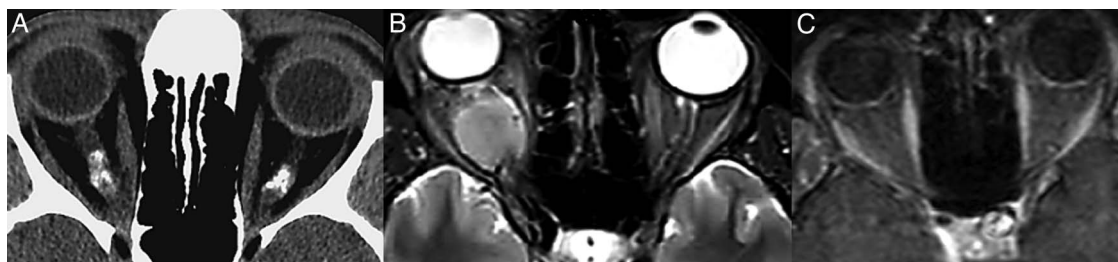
(A) CT of the orbits (axial view) revealing calcification of the optic nerves in optic nerve sheath meningiomas. (B) MRI of the orbits (axial view) revealing a right optic nerve glioma. (C) MRI of the orbits (axial view) revealing an internal carotid artery aneurysm compressing the left optic nerve at its exit from the optic canal.
